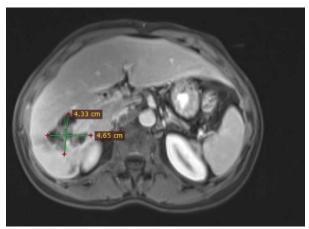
Shows measurement of baseline MRI in segment VI of liver
